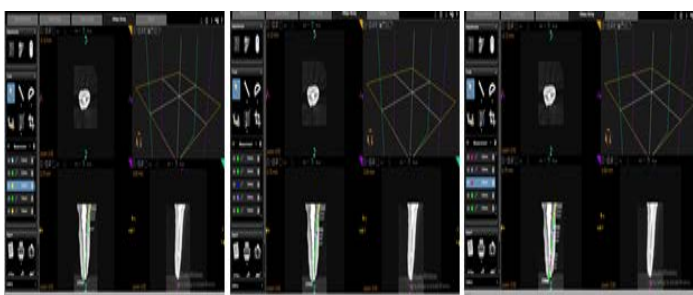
(a), (b), (c): Showing the Pre-CBCT measurements of gutta percha in the coronal, middle, apical portion using RECIPROC respectively
